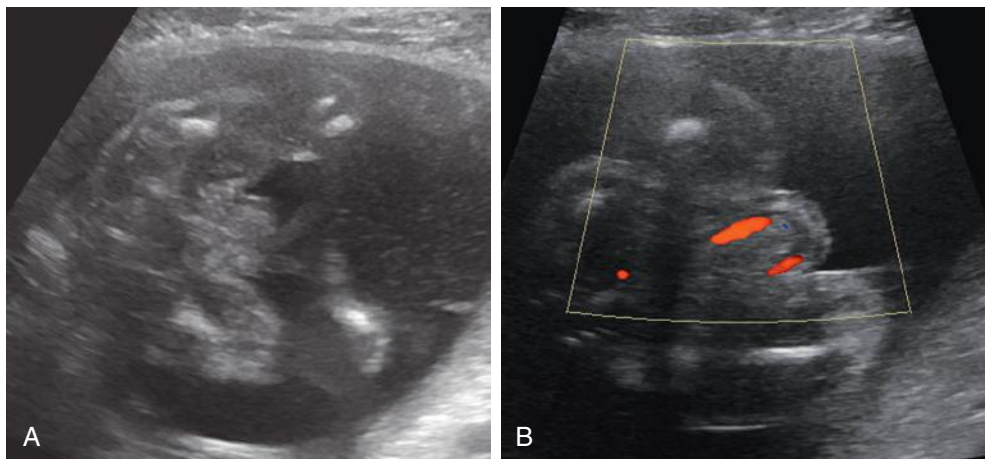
Bladder exstrophy. A, Axial view of lower abdomen showing absent bladder in the pelvis and a soft tissue mass (the exstrophied bladder) in the anterior lower abdomen. B, Nonvisualization of fetal bladder in the pelvis is aided by color Doppler demonstration of the umbilical arteries.
